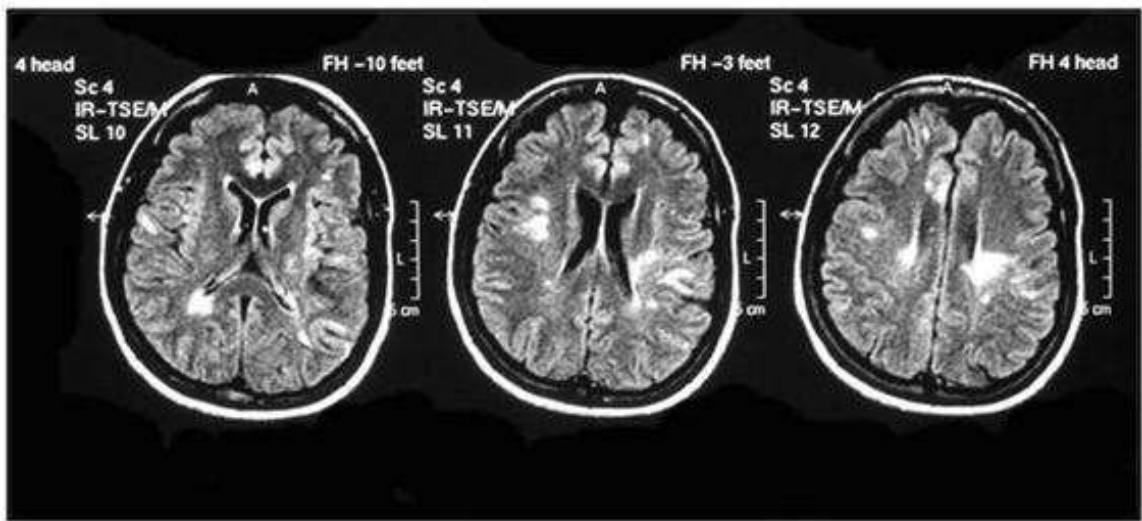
MRI flash fair image: hyperdense lesions in the yuxtacortical area bilaterally, as well as in the semioval centre and periventricular matter.
